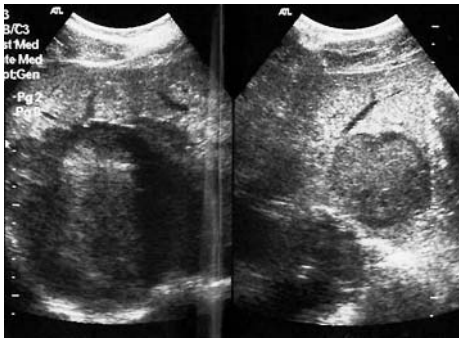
Abdominal ultrasound showing large hyperechoic lesions in the liver of the first patient.
